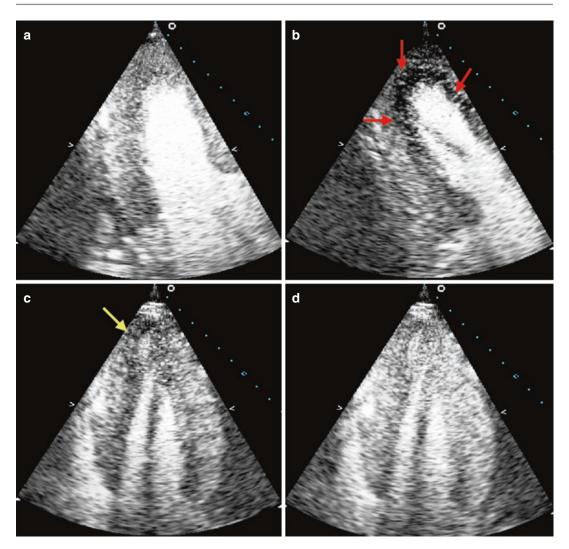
Contrast destruction-reperfusion study during dobutamine stress echo in a patient with 70% lesion at mid portion of the left anterior descending artery and severely diseased right coronary artery with a 90% lesion. Panels (a) and (b) are end-systolic apical two chamber views at rest three beats post destruction (a) and at peak stress one beat post destruction (b). A significant subendocardial defect is seen in the anterior, apical and inferior
